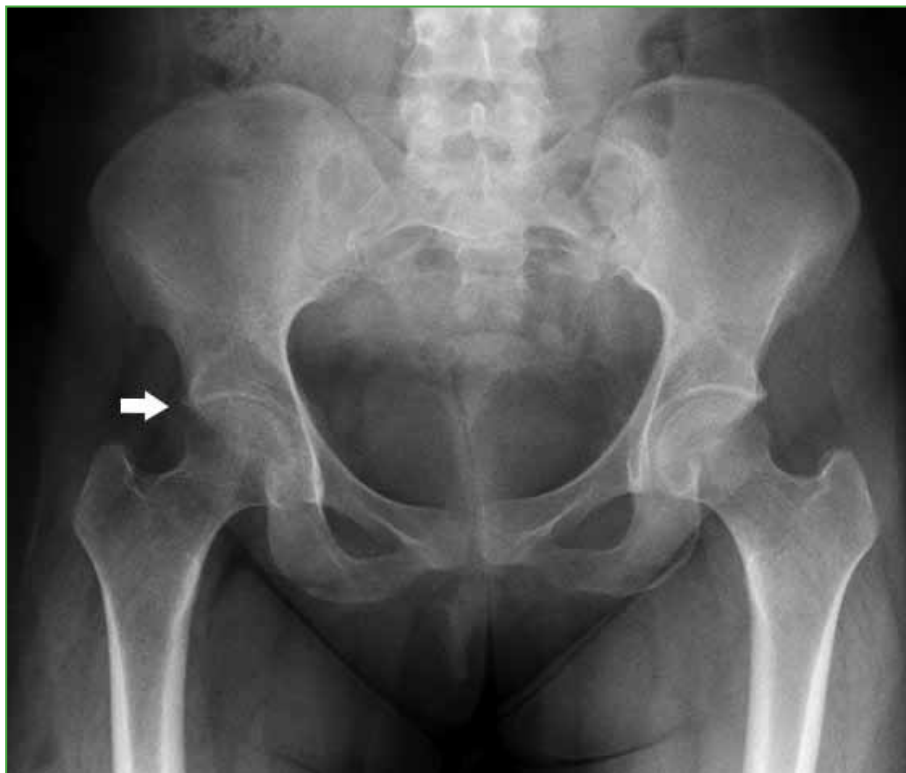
Panoramic pelvic radiograph. Incipient arthritic changes with acetabular overcoverage are observed (arrow).
